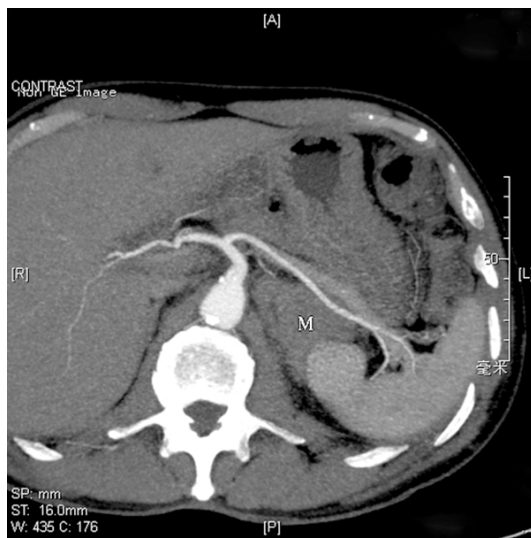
Axial CT maximum intensity projection (MIP) image demonstrates absence of a pancreatic body and tail around the splenic artery and vein, a lack of splenic artery branches to the dorsal pancreas, and a left adrenal metastatic tumor (M).
